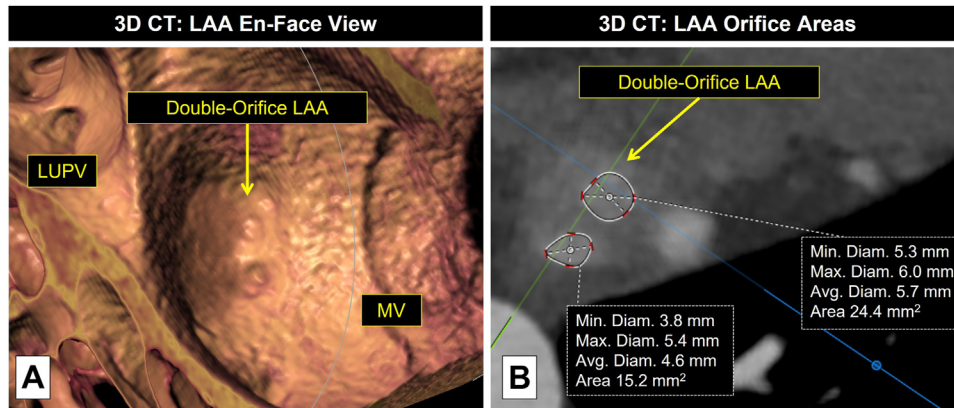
Double-orifice LAA on CCT. (A) CCT, 3D volume-rendered display of the left atrium and LAA, en face view, demonstrating the double-orifice LAA (arrow). (B) CCT, multiplanar reconstruction display, demonstrating detailed measurements of the two orifices of the LAA (arrow; 15.2 and 24.4 mm²). Avg., Average; CT, computed tomography; Diam., diameter; LUPV, left upper pulmonary vein; Max., maximum; Min., minimum; MV, mitral valve.
